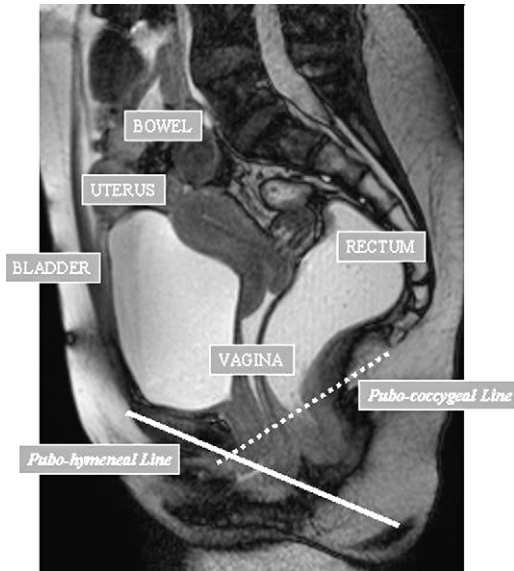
Dynamic MRI defecography. Spontaneous visualization of bladder and small bowel. Vagina and rectum were opacified by hydric contrast. Sagittal view showing the pubococcygeal and pubohymeneal lines.
